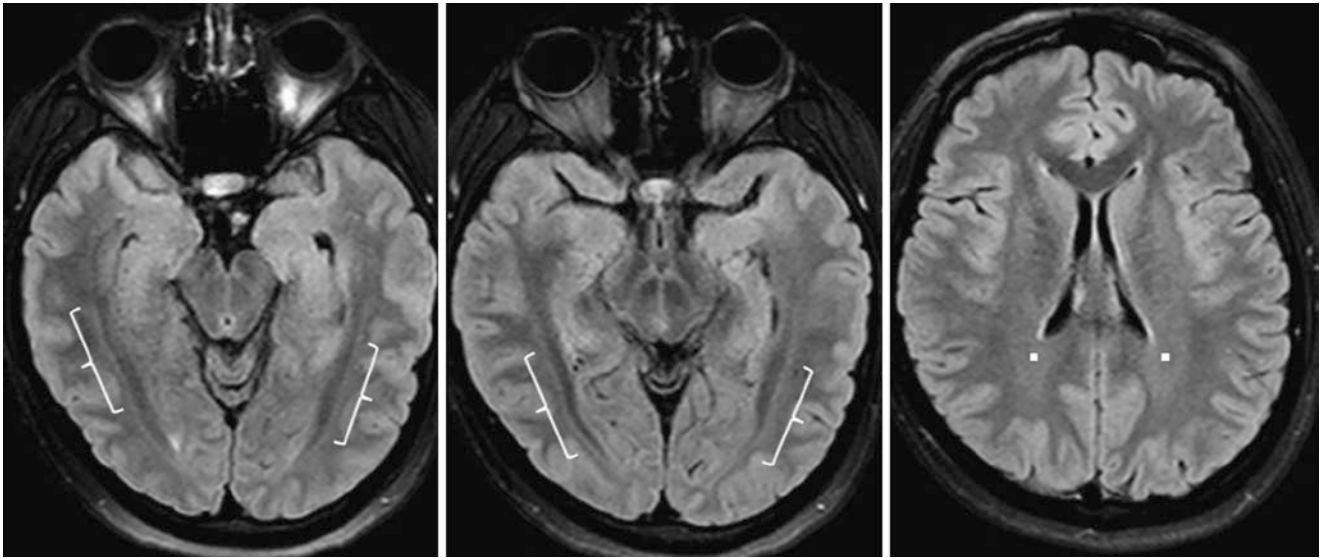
A 15-year-old with headaches had a normal 3T MRI with axial FLAIR images that demonstrated bilateral, subtle terminal zones along the optic radiations (*brackets*). Also, note slight residual hyperintensity within the normal PTWM terminal zones (*squares*)
